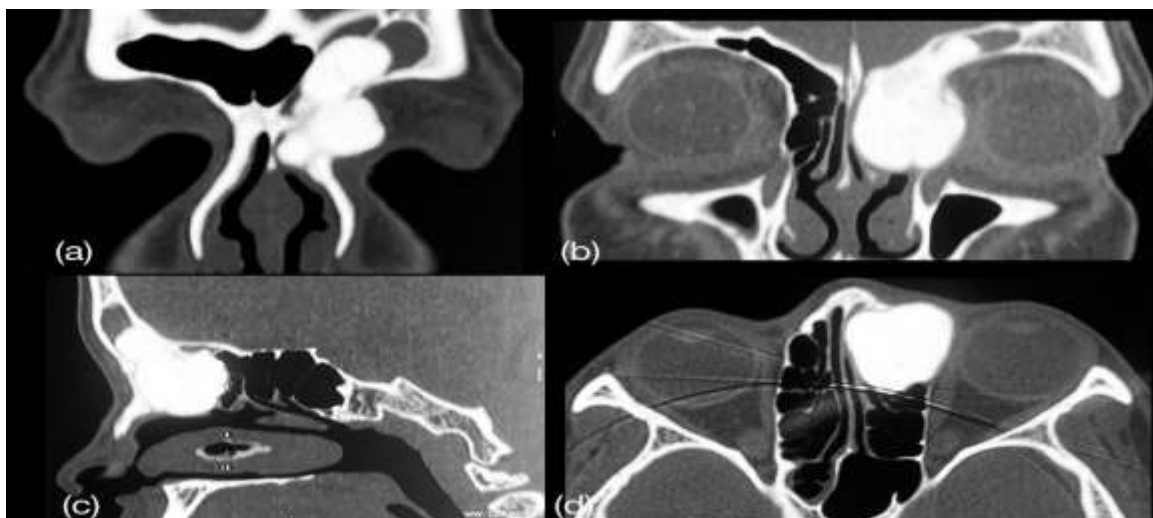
CT PNS revealed a homogenous, densely ossified, well circumscribed lesion involving the left frontal and ethmoid sinuses seen in the coronal section (a) (b), Sagittal section(c) and axial section (d), Compression of the lacrimal sac and nasolacrimal duct and thinning of the medial orbital wall identified in the coronal section(b);Indentation of the medial rectus muscle seen in the axial section (d).
